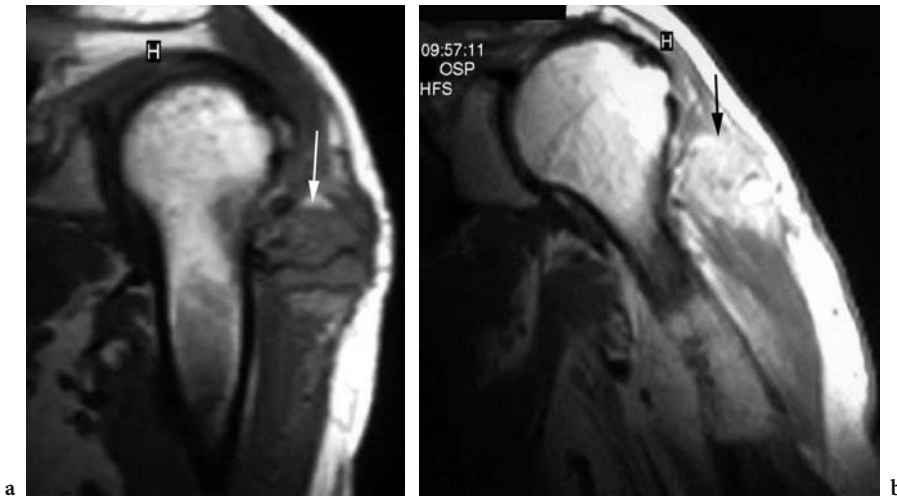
Muscle metastasis in a 63-year-old man with clear cell renal carcinoma 3 months after radical nephrectomy and who presented with deltoid swelling and paraneoplastic erythrocytosis. a Coronal unenhanced T1-weighted MR image shows an ill-defined and slightly hyperintense oval mass involving the left deltoid muscle (*arrow*). b Sagittal contrast-enhanced T1-weighted MR image shows strong enhancement of the mass (*arrow*). There is no adjacent involvement of the skin. (Image courtesy of A. ALIMONTI and S. TORMENTA)
